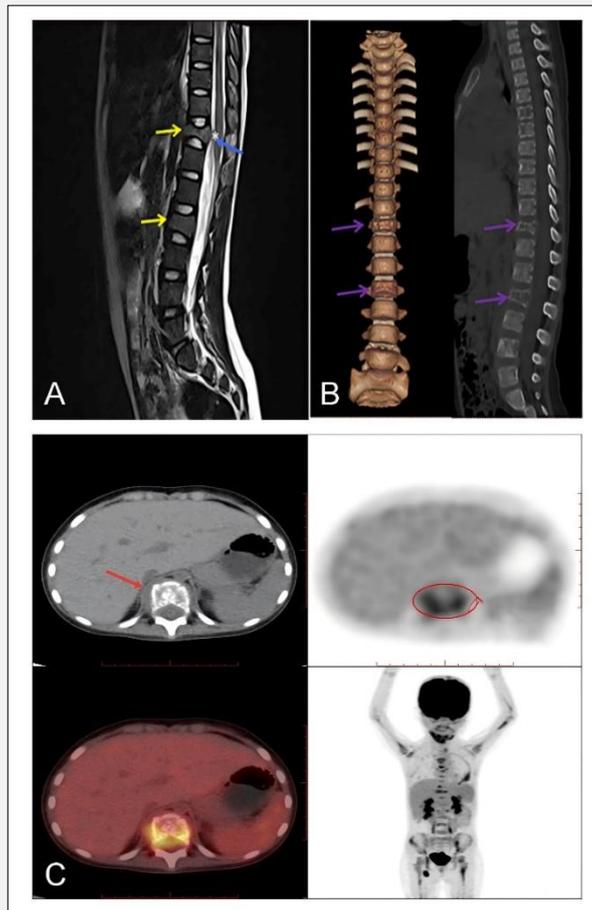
A Sagittal T2 MRI showing T11/L2 vertebral collapse (arrow) with epidural extension (arrow). B 3D reconstruction of lytic lesions (arrow). C Axial PET-CT (SUVmax 2.7) with paraspinal mass (arrow). Quantitative PET metrics of the target lesion. Maximum standardized uptake value (SUV max): 2.706, volume: 16.9 cm³, total lesion glycolysis (TLG): 27.7 (circle).
